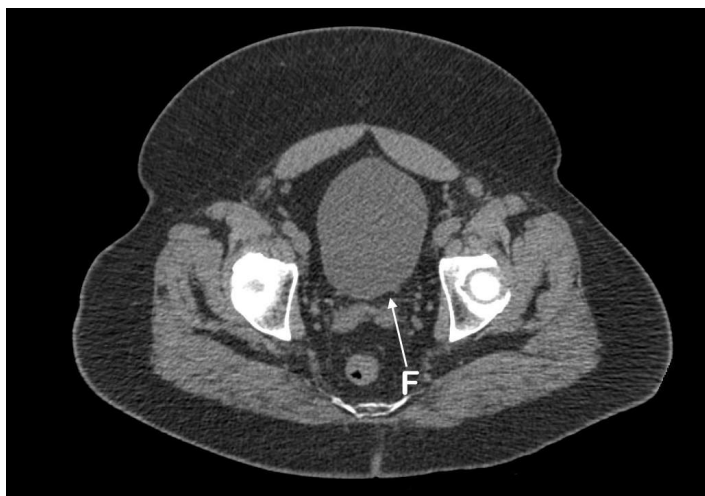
Computed tomography (CT) of the abdomen and pelvis (CT KUB). Flattening (F) of the left posterior bladder wall.
